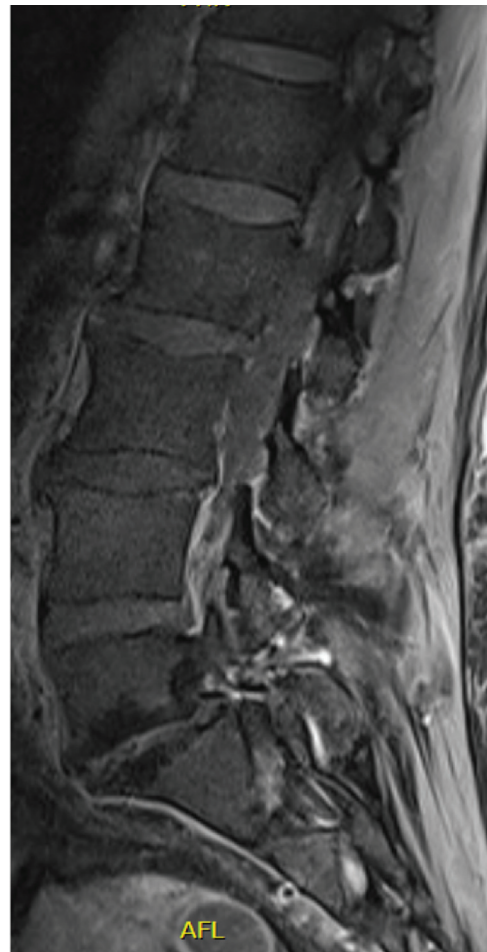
Initial lumbar spine magnetic resonance imaging (MRI).
